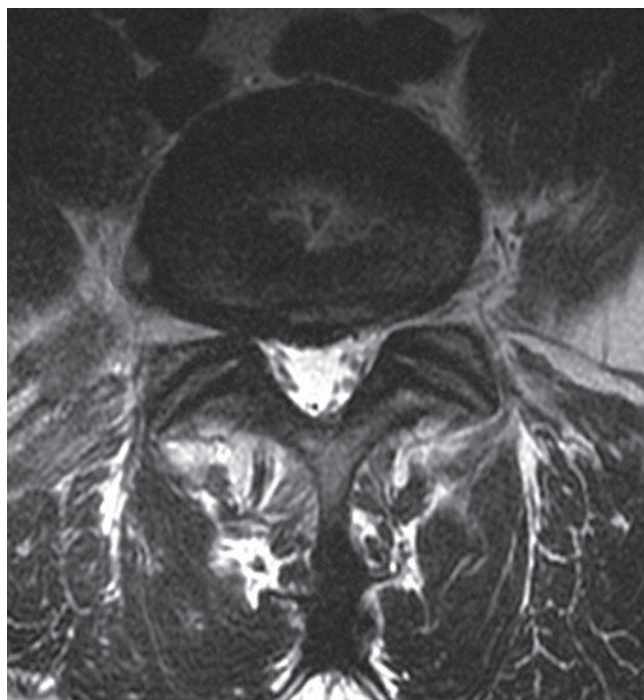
This axial T2-weighted image shows a broad-based disc protrusion at the L4-L5 level with a far-lateral component that contacts the extraforaminal course of the right L4 nerve root. The patient presented with paresthesias in the medial right foot and weakness with dorsiflexion. Functionally, the patient was unable to perform an adequate heel walk.
